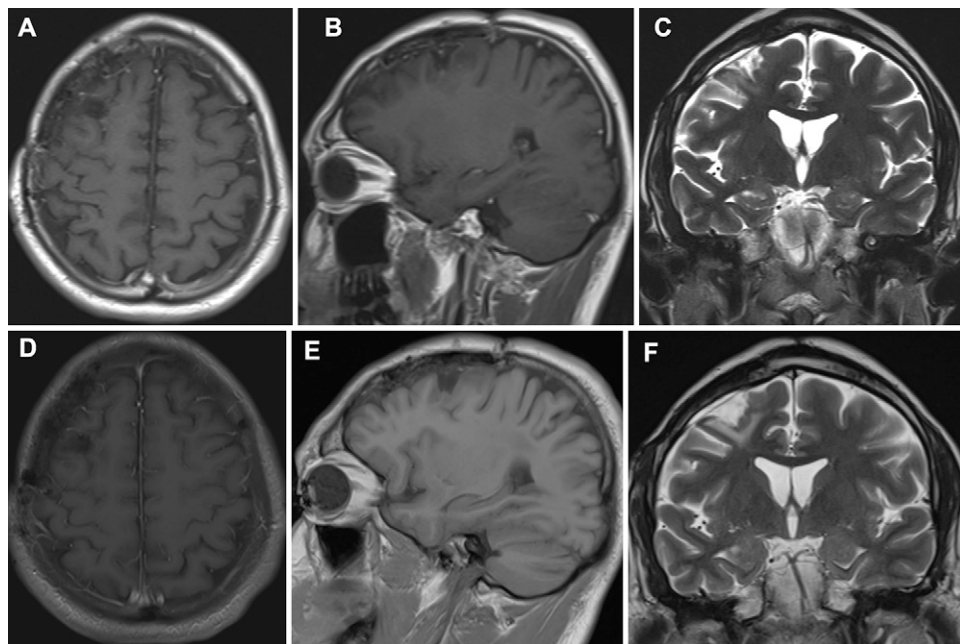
One-year (A–C) and 2-year (D–F) postoperative MRI showed no signs of tumor recurrence.
